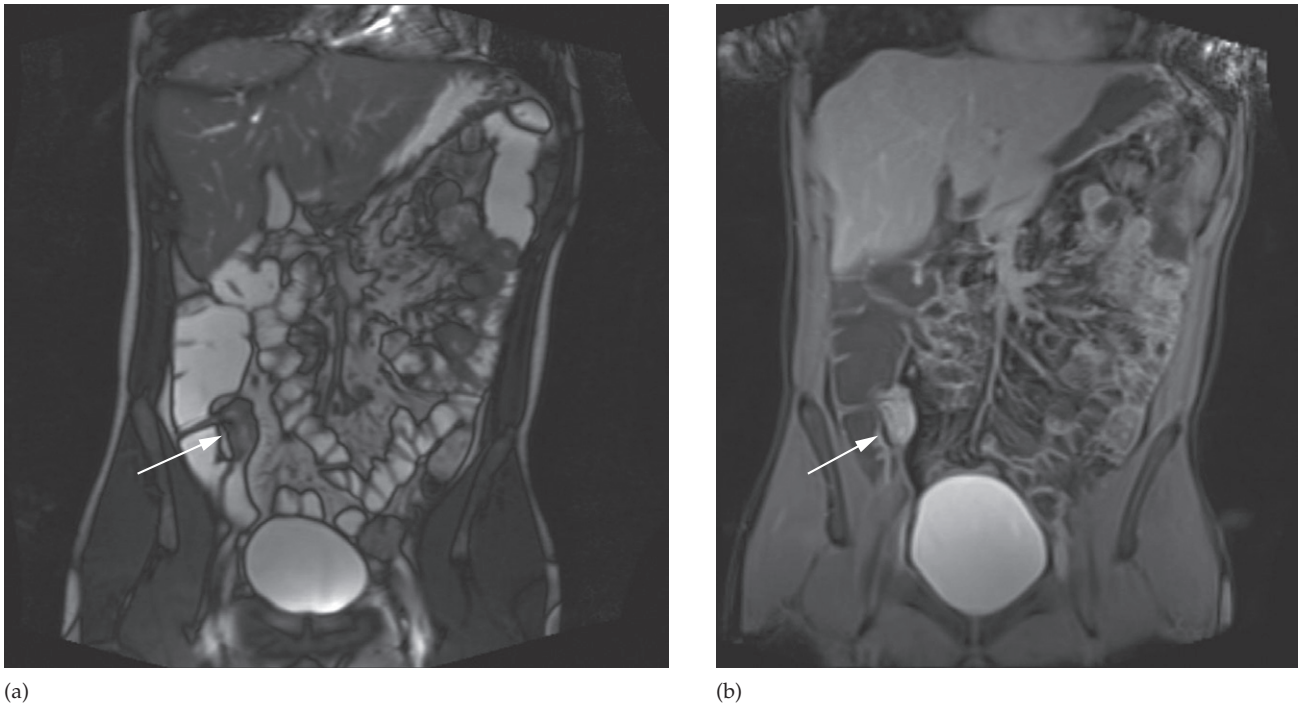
MRI of Crohn's disease. (a) Coronal T2 and (b) coronal T1 post contrast images demonstrating mucosal thickening and enhancement involving the terminal ileum (arrows), characteristic of Crohn's disease.
